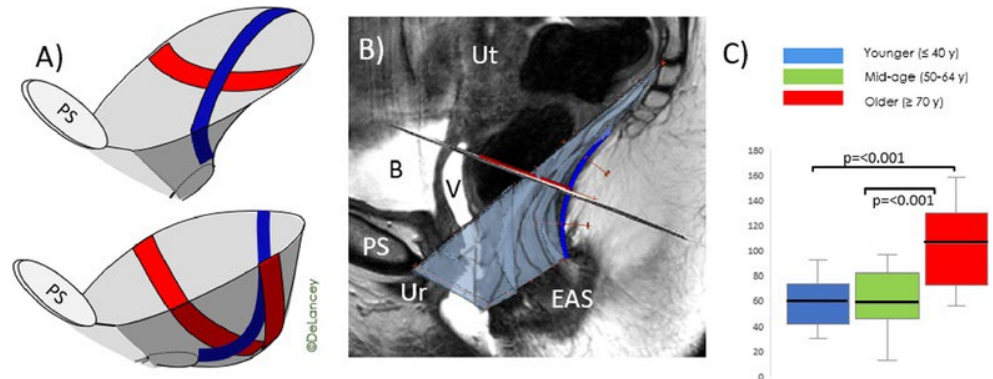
A) Conceptual model for age-related pelvic floor changes, representing the levator plate (blue band) and ICM (red band). B) Mid-sagittal MRI with blue line showing the levator plate. Axial plane tipped to measure in plan of ICM. Levator bowl volume is demonstrated. Pubic symphysis (PS), bladder (B), urethra (Ur), vagina (V), uterus (Ut), external anal sphincter (EAS). C) Average levator bowl volumes for young, middle-aged, and older nulliparous women.
